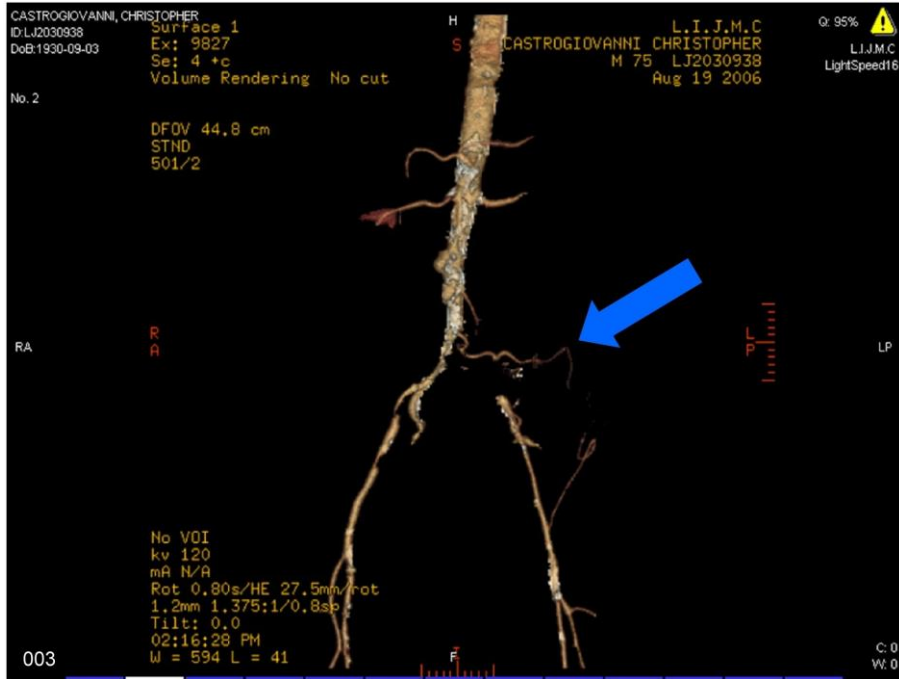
CTA film showing occlusion of left common iliac artery (arrow) with disease at the contralateral iliac artery.
